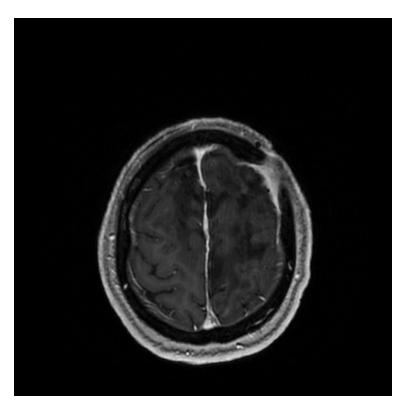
Postoperative MRI scan. Axial T1 weighted image post-Gd administration. Data on tumor residual tissues are not obtained. Post-therapeutic gliosis can be visualized, as well as small remnants of haemorrhages in the post-operative areas.
